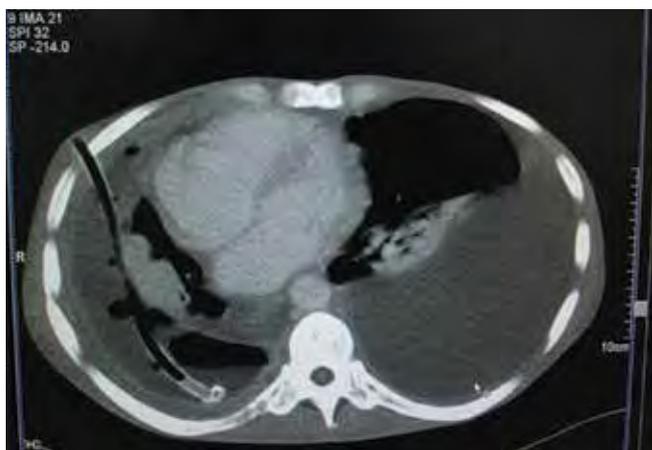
Computed tomography scan of the chest showing bilateral pleural effusions with consolidation of the right lower zone of the lung with thickened pleura and intercostal drainage tube in place. No significant pulmonary nodules or lymphadenopathy are visible.
